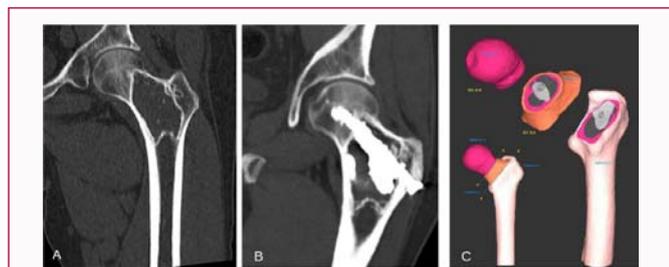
The lateral CT scan shows large lytic metastasis of the neck of the left femur (a). The same scan after treatment shows screw fixation plus cementoplasty (b). In order to obtain a greater understanding of the internal behavior of the structure and to highlight the stress state of its most stressed points (neck of the femur and trans-trochanteric region) the model was divided into three regions, corresponding to: LAYER 1 - head of the femur; LAYER 2 - neck of the femur; LAYER 3 - diaphyseal region of the femur (c).
